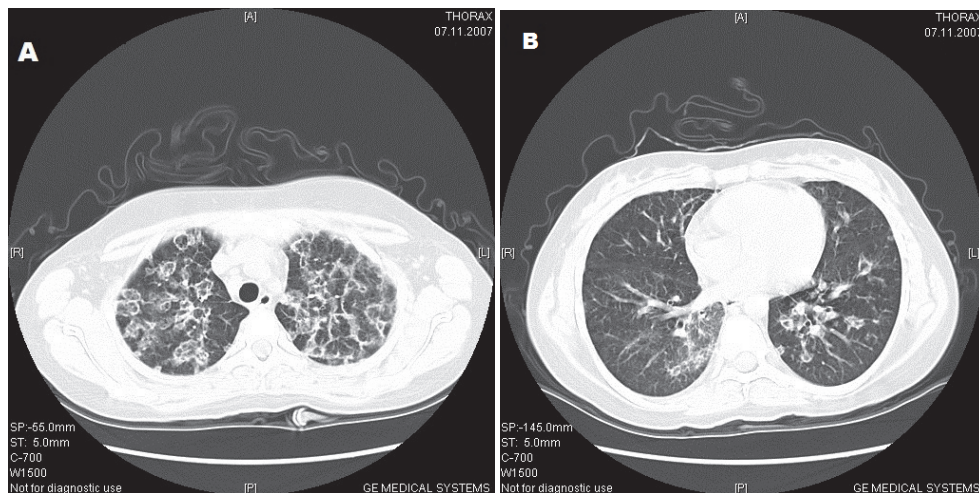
A, B. Chest CT scan of patient #1 (A – middle, B – lower parts): non-specific interstitial pneumonia with supervened infection.
